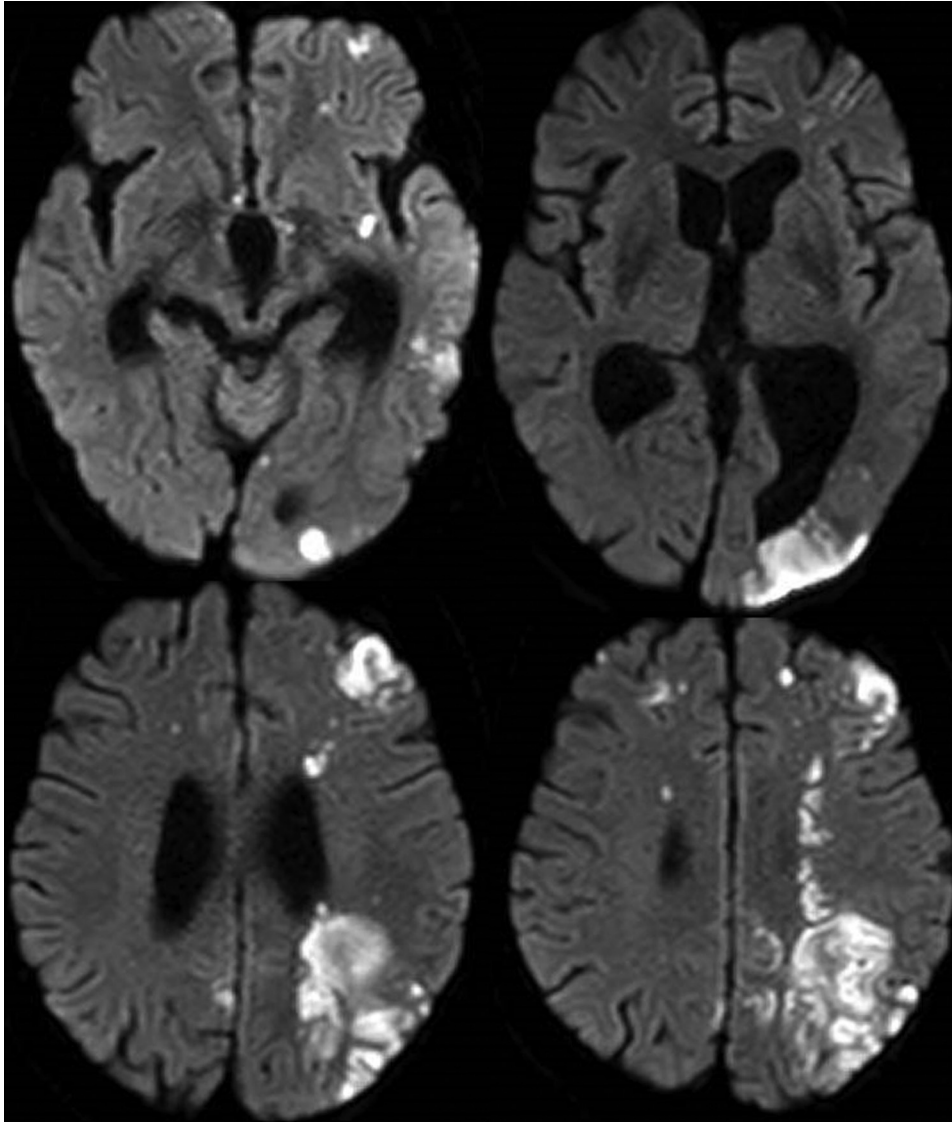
Axial diffusion-weighted magnetic resonance image one day after endovascular treatment showing ischemic lesions in the watershed area of the middle cerebral artery.
